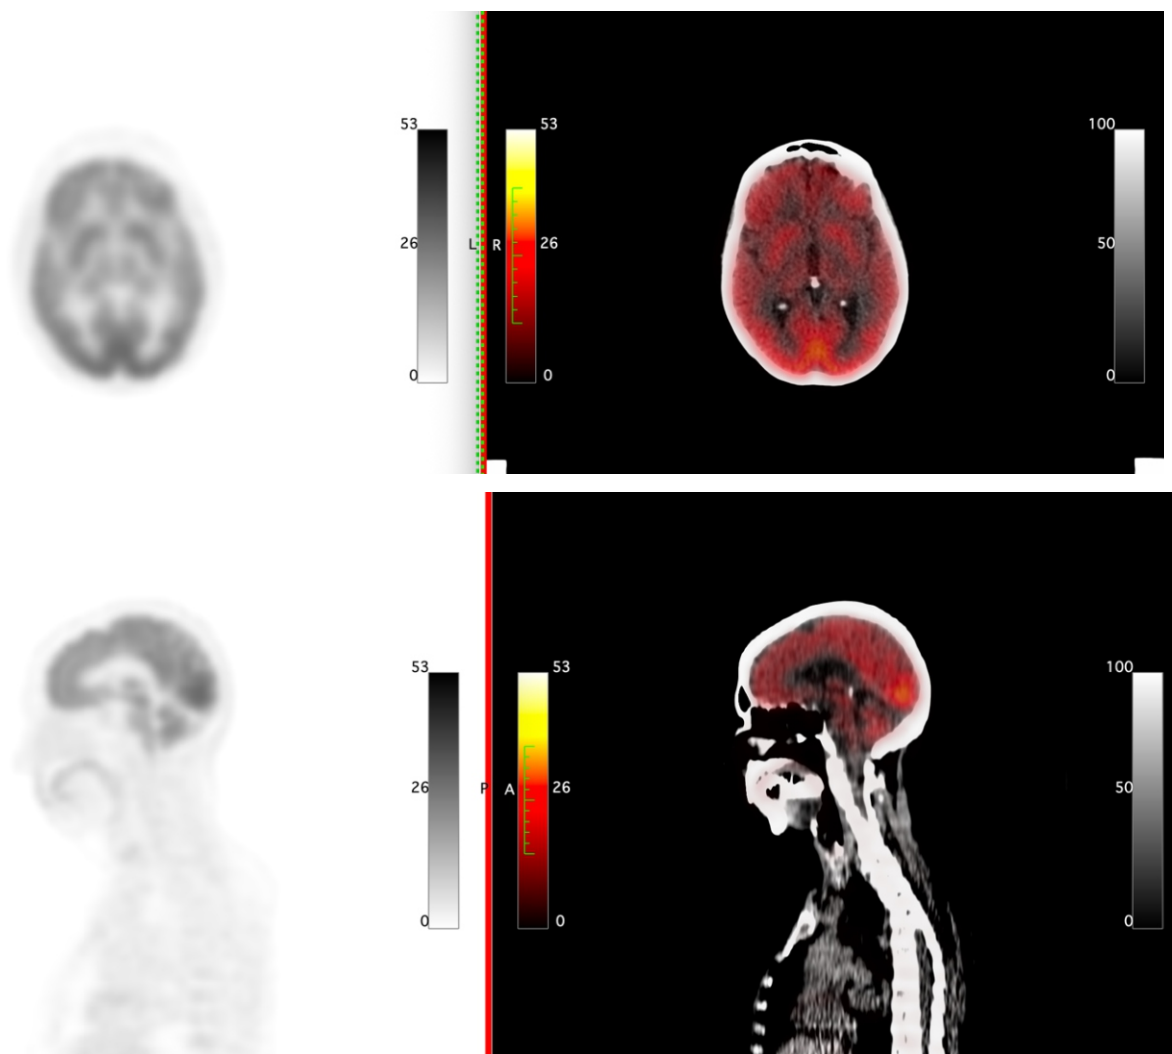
Restaging (Panel A,C) ^{18}F -FDG PET and (Panel B,D) PET/CT scans 4 months after baseline imaging. Reduced glucose metabolism is seen in the cingulate gyrus, cerebellum, pons, and temporal regions. In contrast, the occipitoparietal region demonstrates marked hypermetabolism bilaterally.
